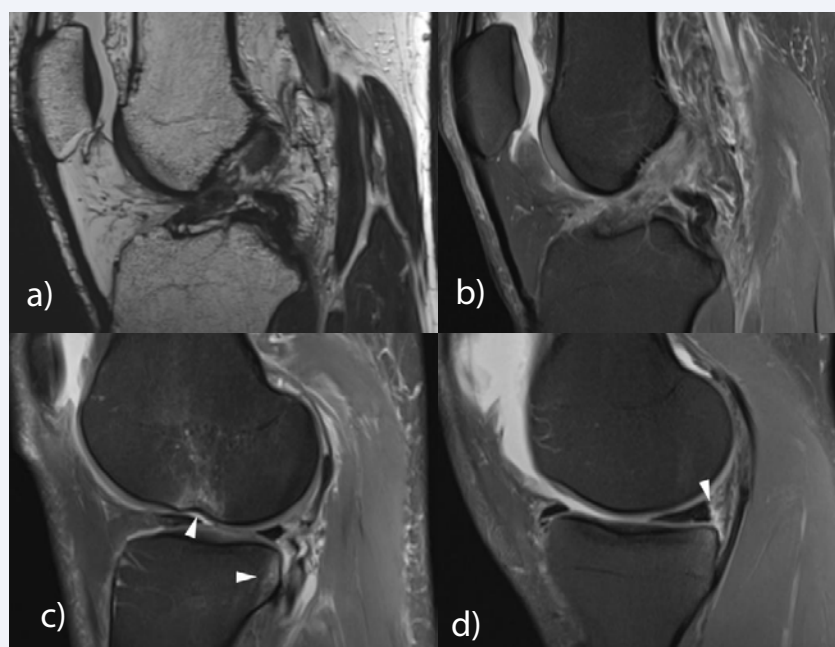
Primary and secondary signs of ACL tear. (A) Sagittal T2-weighted image shows discontinuity of the ACL at the mid-substance indicating a complete tear. (B) Sagittal fat-suppressed proton density-weighted shows diffuse enlargement and cloud-like hyperintense signal intensity of the ligament, resulting from edema and hemorrhagic change of the ligament. (c) Sagittal image through the lateral compartment shows kissing bone contusion involving the posterior aspect of the lateral tibial plateau and the mid portion of the lateral femoral condyle at the sulcus terminalis, which indicates a pivot shift injury. A slight depression fracture at the sulcus terminalis of the lateral femoral condyle is noted ("deep notch sign") (D) A thin fluid signal is interposed between the posterior horn of the medial meniscus and the posteromedial capsule, leading to the diagnosis of meniscal ramp lesion associated with ACL tear.
